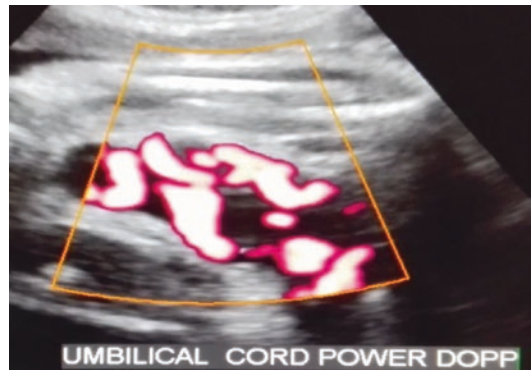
Umbilical cord in power Doppler mode
